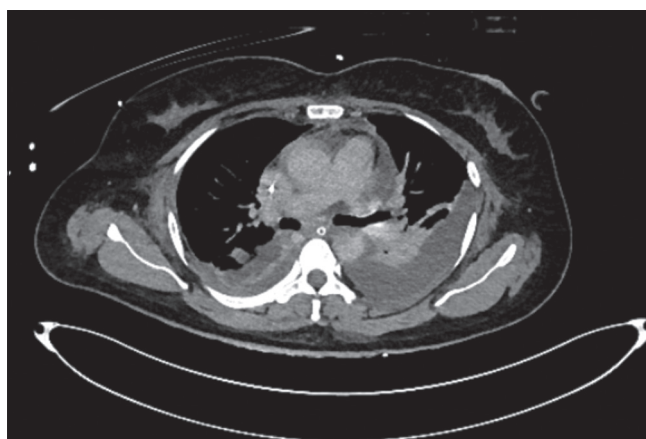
Computed tomography scan of the thorax showing bilateral pleural collections with ground-glass centrilobular nodules in axial view
